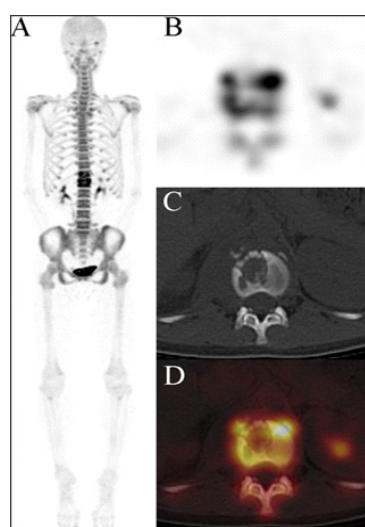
Fluorine-18-NaF PET/CT imaging of patients with spine TB. (A) A 17 years old girl with spine TB. Maximum intensity projection image showed increased ^{18}F -NaF uptake in T12-L1 vertebrae. (B, C and D) The axial images of PET/CT demonstrated that the bone structure was disordered with some osteolytic bony destruction and abnormal activity. Maximum standardized uptake value (SUVmax) was 24.5.
